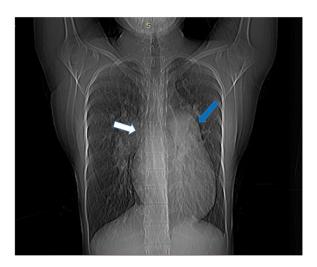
Chest X-ray showing increased cardiothoracic ratio with prominent Pulmonary Bay with enlarged right descending pulmonary artery.
